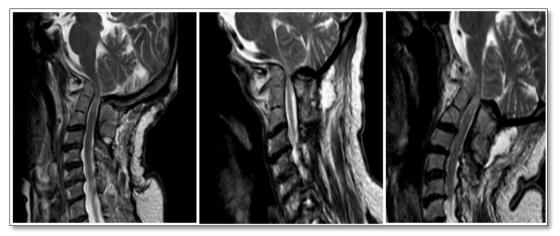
MRI C-spine in flexion and extension showing untreated severe CMJ compression with myelomalacia.
